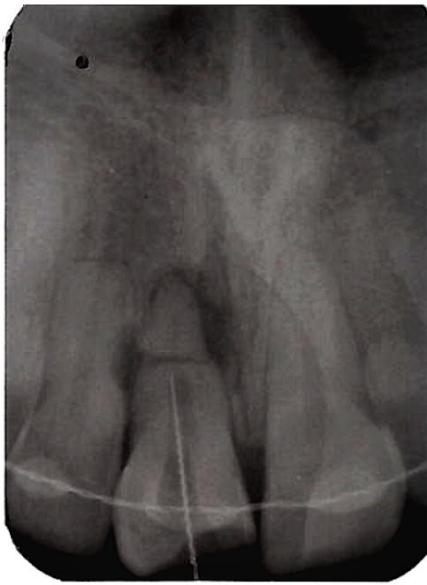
Perioperative radiograph showing determination of the working length.
